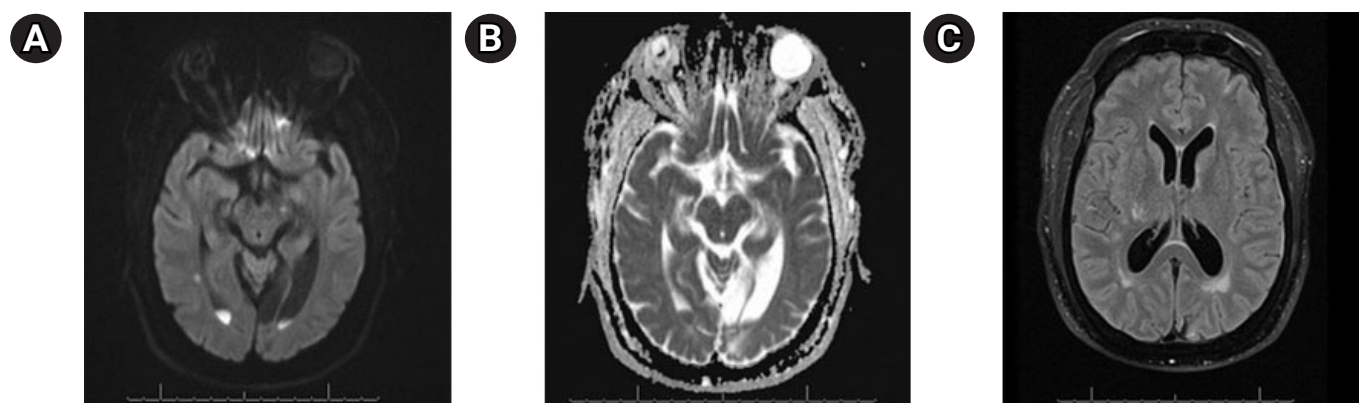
Magnetic resonance imaging with and without intravenous contrast. (A) Evidence of diffusion restriction indicative of ischemia from EP2D sequence. Additional pus material with restriction effusion layering at the posterior horns of lateral ventricles. (B) Apparent diffusion coefficient (ADC) correlate of the same level as panel (A) demonstrating persistent diffusion restriction from EP2D ADC sequence. (C) Evidence of increased fluid-attenuated inversion recovery signal with association enhancement suggestive of diffuse meningitis.
